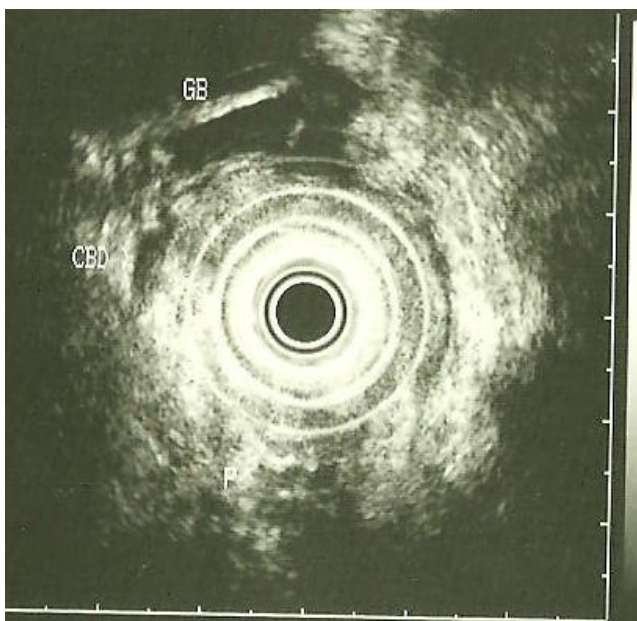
Endoscopic ultrasound.
